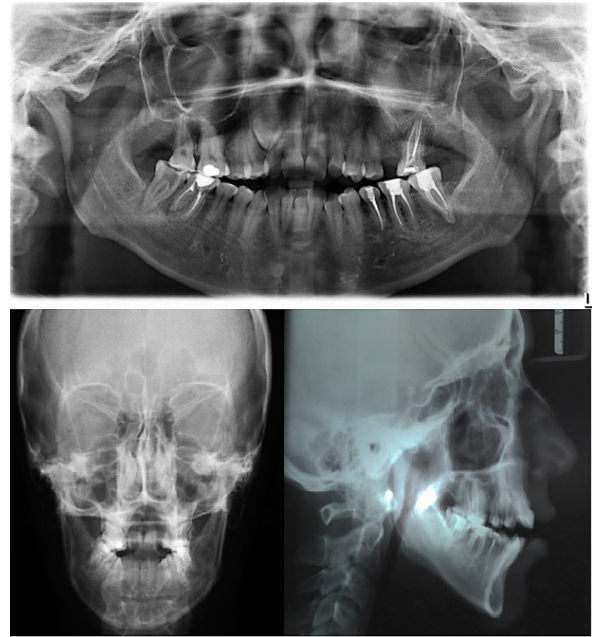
Orthopantomography and Cephalometric images
